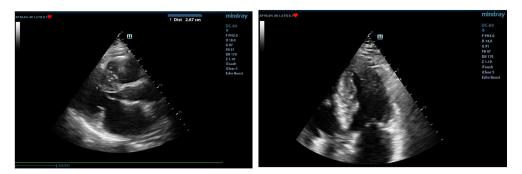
b.1. Marked myocardial hypertrophy localised at the interventricular septum (2.67 cm) and LV apex (2D echo, parasternal long axis and 4-chamber view)
